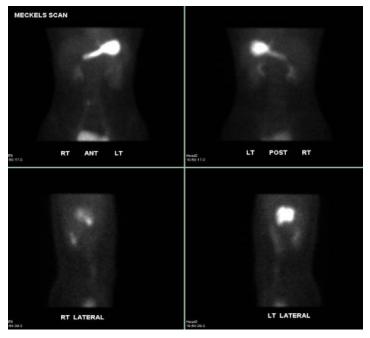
Meckel's scan showed Normal distribution of technetium in the gastric mucosa, kidneys and bladder without scintigraphic evidence of Meckel's diverticulum.
